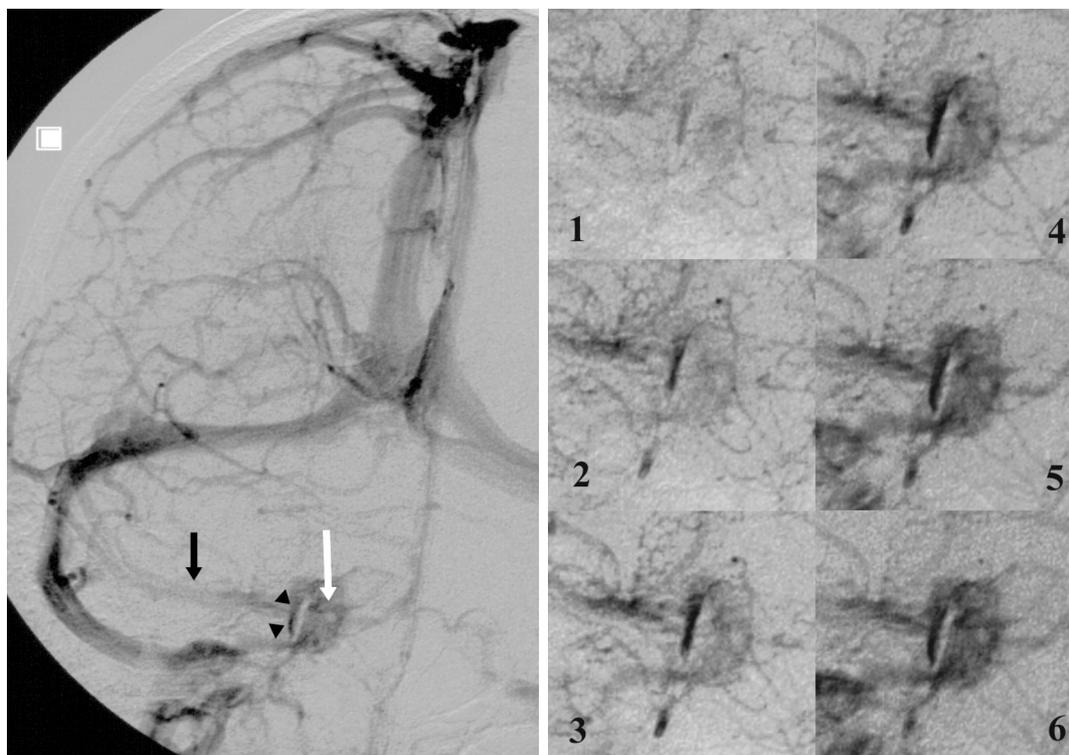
DSA, venous phase, in a 68 year-old man investigated for carotid bifurcation atheromatous disease. 17a. left image. Right common carotid injection, anteroposterior view. A duplicated SMCV (black arrows) drains into a right LCS (black arrowhead). The right CS is opacified as well although no significant connections are observed. Note the linear opacification defect of the inner layer of the CS lateral wall, separating the LCS from the lateral compartment of the CS. A second, round opacification defect is visible within the CS itself, corresponding to the cavernous segment of the right ICA (white arrowhead). This anatomic landmark allows discerning the medial and lateral compartments of the CS. 17b. right image. Magnified view of the right laterosellar venous spaces. This dynamic sequence (1 to 6) was acquired at the rate of 1 image per sec. Note that the LCS appears early in the sequence while the medial and lateral compartments of the CS show homogeneous opacification after a delay of approximately 5 seconds. This is consistent with the findings of Bonneville et al (1991), who observed during dynamic CT of the laterosellar venous spaces a delay of 5 seconds between visualization of distinct laterosellar veins and homogeneous opacification of the CS. Note on the last image of the sequence the particularly well-delineated inner layer of the CS lateral wall.
